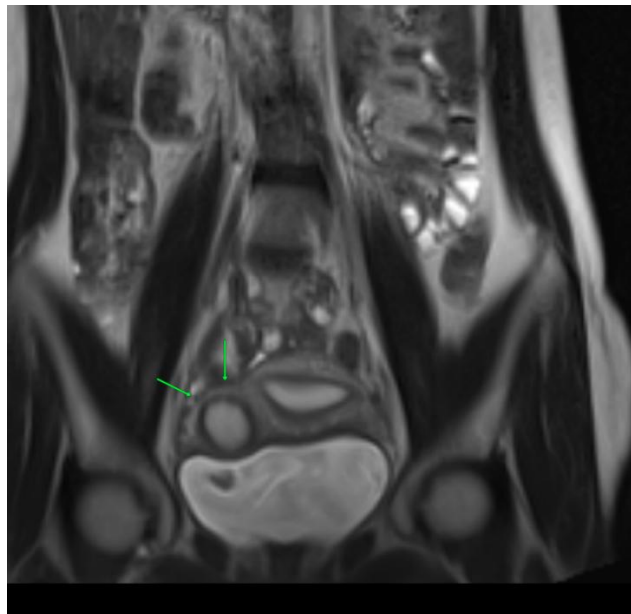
Coronal T2-weighted magnetic resonance image confirming the cornual location of the accessory mass (green arrows), demonstrating a completely normal central endometrial cavity with no communication pathways.
